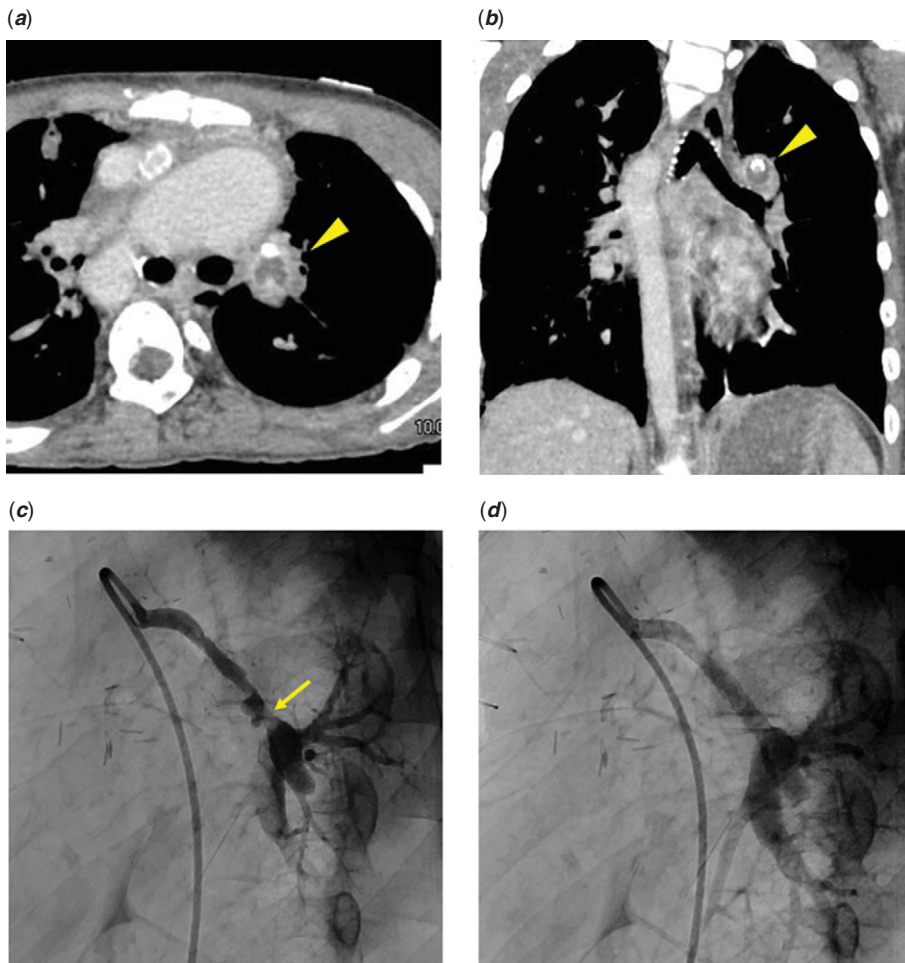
Axial and coronal view of CT scan showing the left-sided systemic-to-pulmonary shunt encapsulated by a low-density area suggesting the abscess (a, b). Lateral view of the left-sided shunt before and after stent implantation (c, d). The yellow arrowheads indicate the abscess around the shunt, and the arrow indicates the stenosis of the shunt and the distal anastomosis to the native pulmonary arteries.
